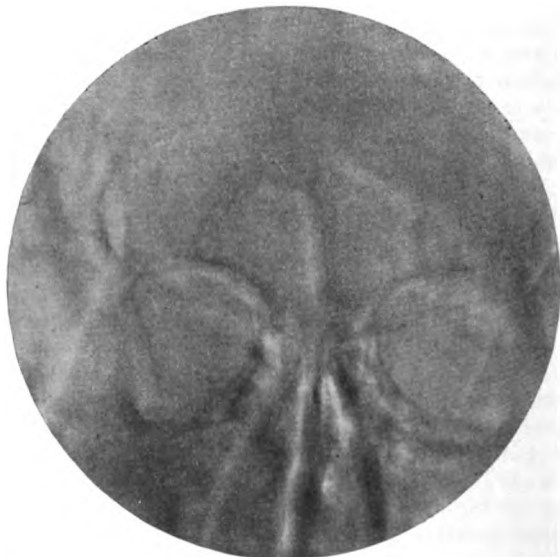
Plastic radiograph of the frontal and other sinuses of the face.
